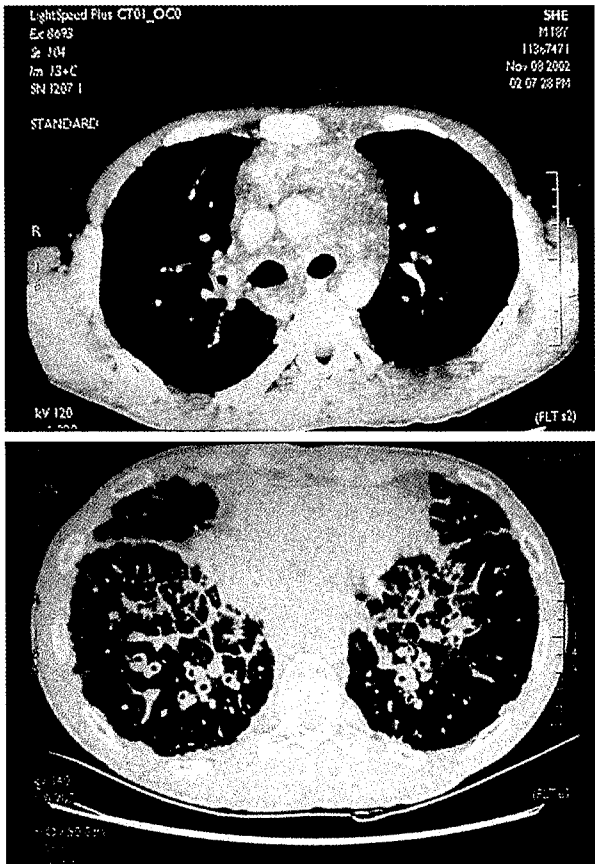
Chest computerized tomography (CT) reveals: (1) Diffuse interstitial thickness and nodulation mainly in the interlobular septum. (2) Irregular thickness in the bronchovascular bundles, and subpleural surface of the bilateral lungs. (3) Widening of the mediastinum with diffuse veining opacities, consistent with hypervascularity.
